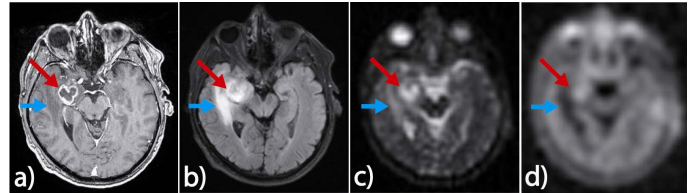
Images of a glioblastoma patient. a) contrast-enhanced T_1 -MPRAGE b) T_2 -FLAIR c) ^{23}Na -DA-3DPR-conc. d) ^{23}Na -FLAIR (TE/TR = 0.75/124 ms; TI = 34 ms; resolution: (5 mm)³; Hamming-filtering; $T_{AQ} = 10$ min 20 s). One part of the lesion is suppressed in the ^{23}Na -FLAIR image, whereas the other part shows high signal intensity.
